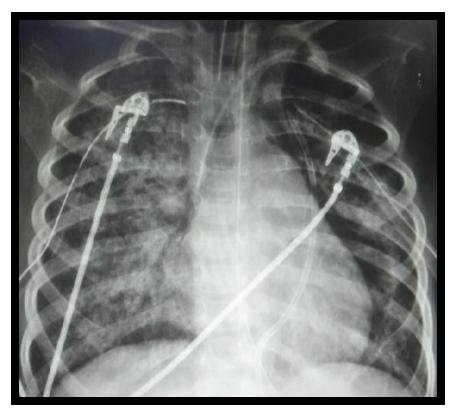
X-ray AP Thorax Increase in micronodular infiltrates of bilateral undefined margins, compatible with PARDS.
